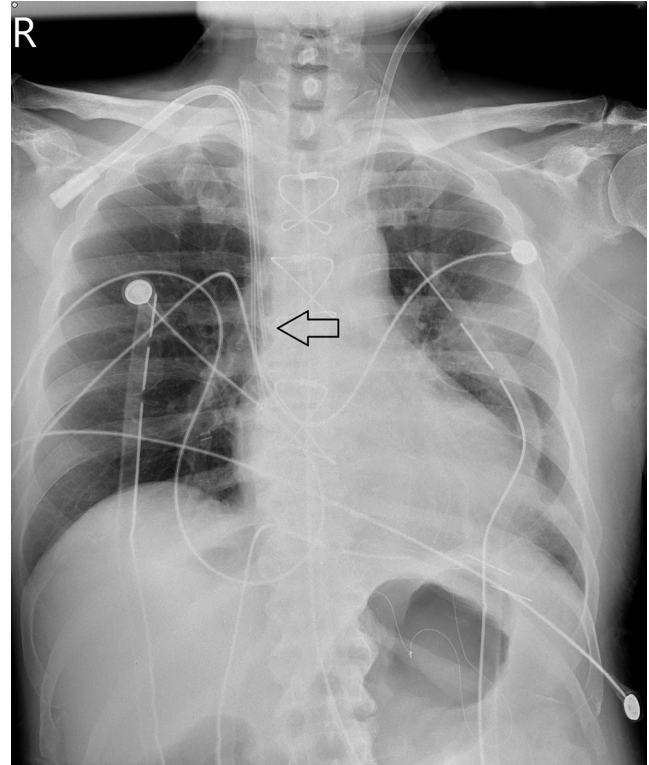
Chest radiograph after successful radiologic procedure to reposition the Perm catheter, showing the tip back in the original place (black arrow).
